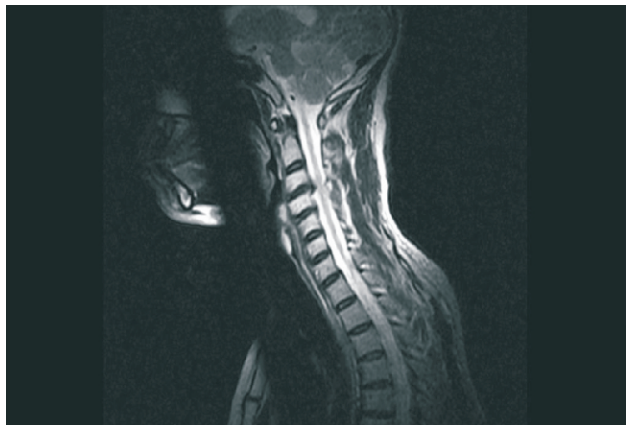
MRI showing disc prolapse at C3/C4 level
